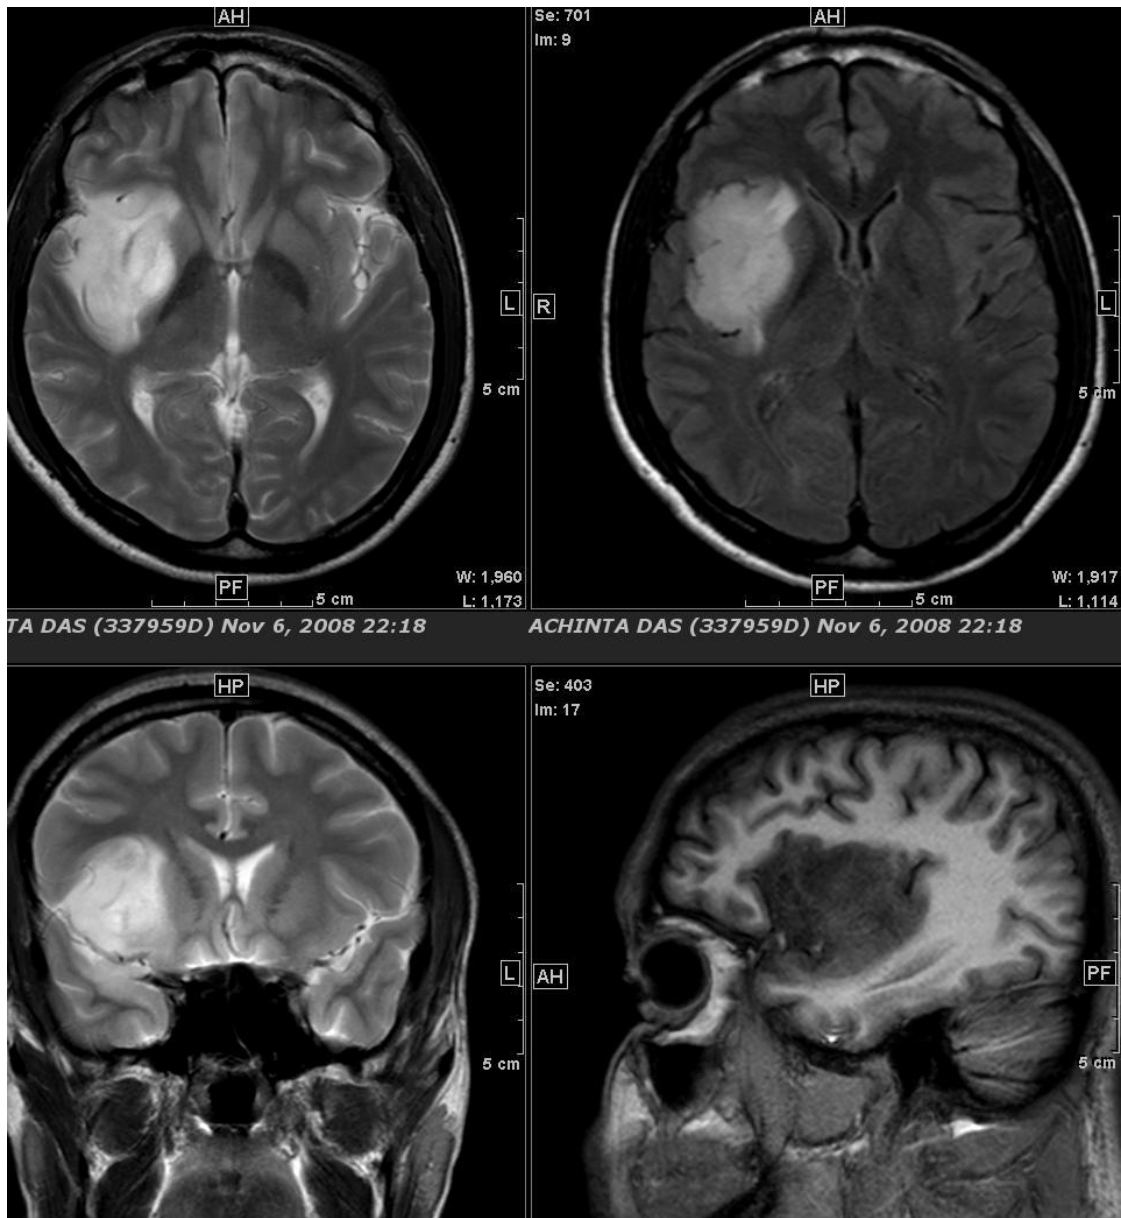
Magnetic resonance imaging in a patient with a right insula glioma displaying a distinct tumor-brain interface with perilesional edema on the T2 axial and coronal (a&c) images, T2 flair (b) and T2 sagittal images (d)
